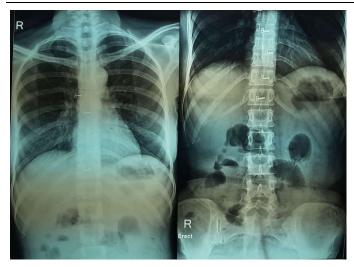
X-rays of chest(AP view) and abdomen(erect)
